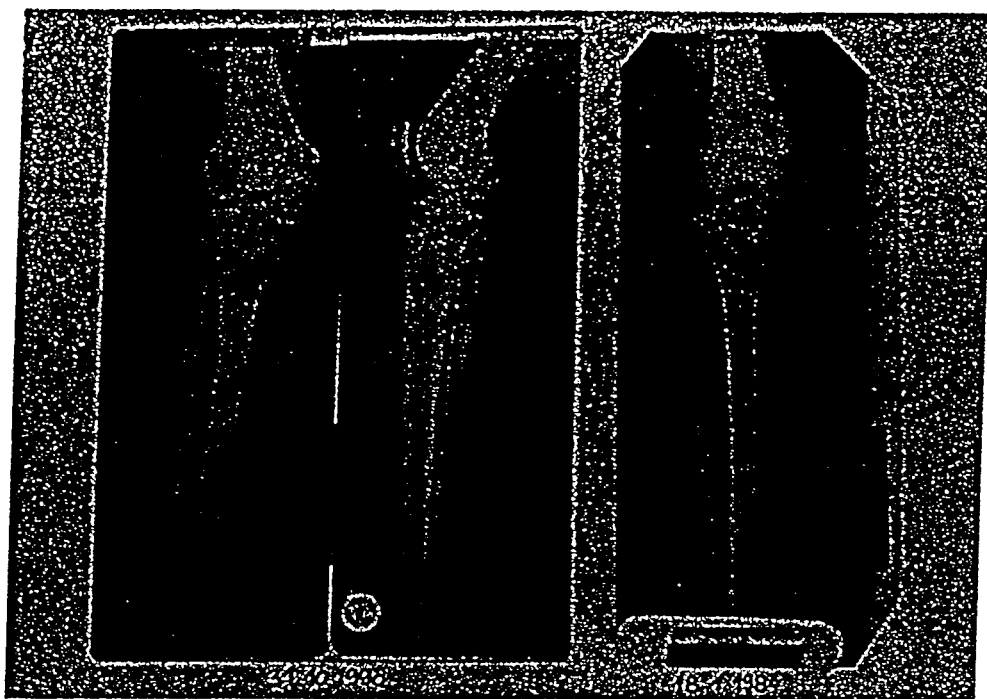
Comparative X-rays: 31 Oct. 1990 and prior to therapy (18 Jan 1984).
